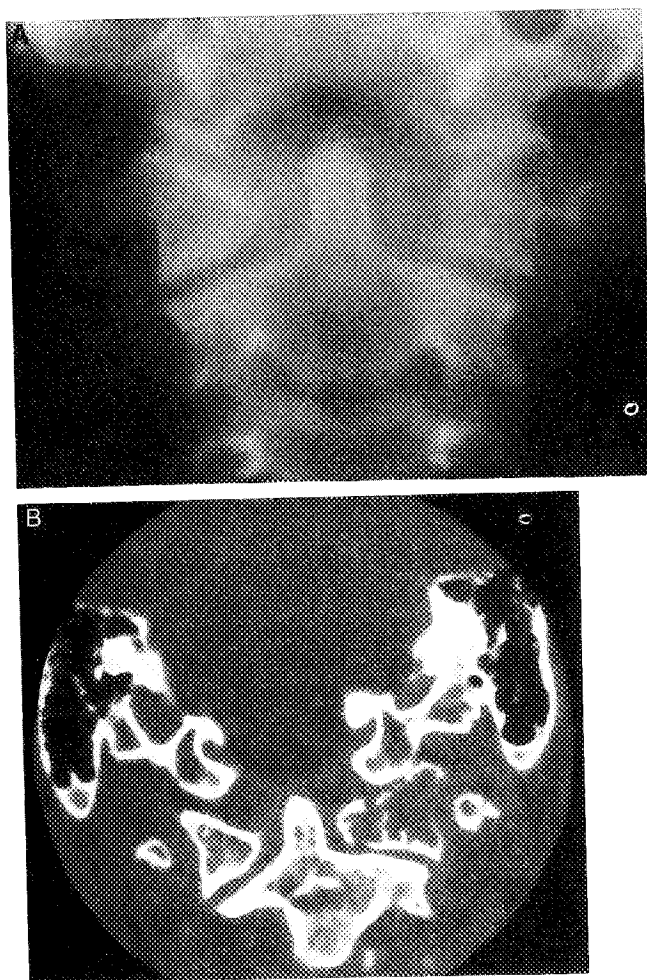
Monostotic fibrous dysplasia of C1 (19-year-old man). A, Anteroposterior tomogram of C1 shows an expanding lytic lesion with coarse trabeculation in the left lateral mass. B, Computed tomography scan of C1 shows a well defined lytic lesion with coarse trabeculation and a pathologic fracture of the left lateral mass.
